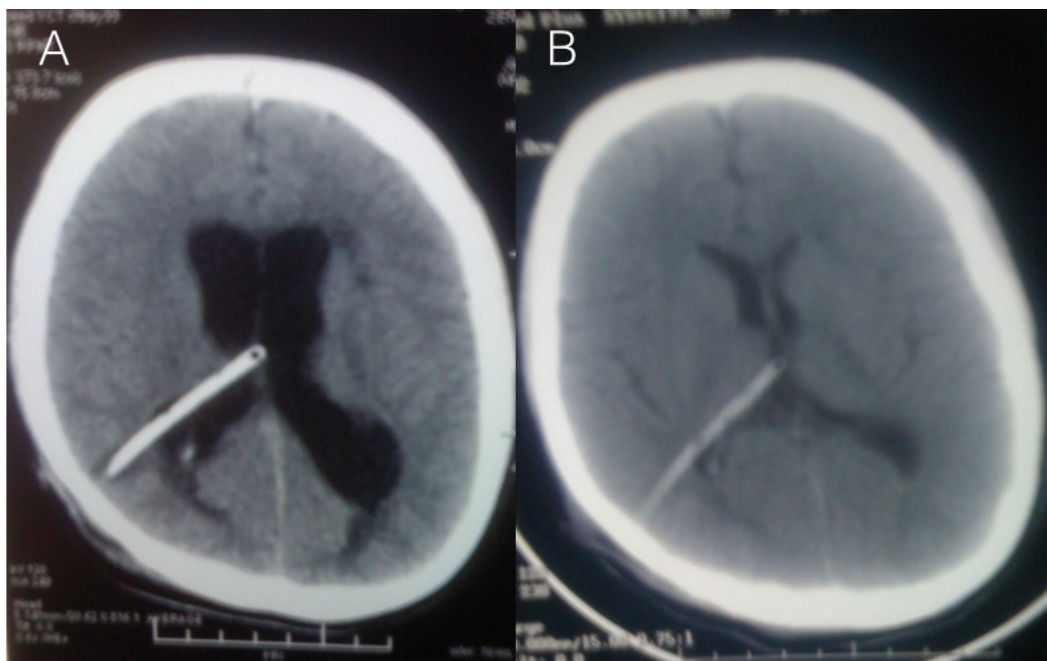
CT of the brain of a previously shunted 12-year-old male with aqueductal stenosis that had signs of increased tension and VP shunt failure; the CT shows enlarged ventricles (A) where ETV was performed without removing the shunt. Follow-up CT of the brain 3 months afterward showed decline in the ventricular size (B) which was accompanied by clinical improvement of the patient.
